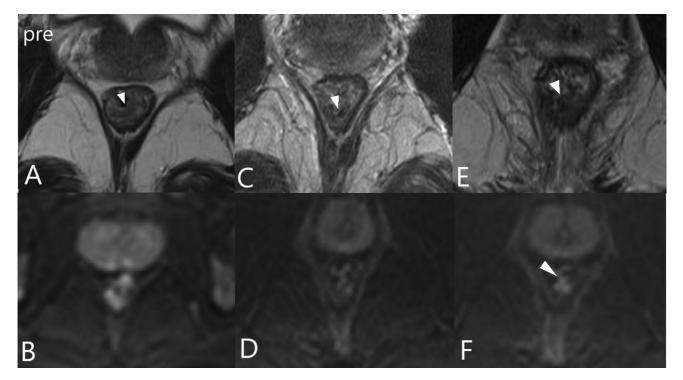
Regrowth after 9 months of complete response in an early stage (cT1, N0) low-rectal cancer following neoadjuvant long-course chemoradiotherapy (LCRT) with 54 Gy. (A, B) Baseline T2 high-resolution (HR) and diffusion-weighted imaging (DWI) (b800) show a left posterior semiannular intermediate signal intensity diffusion restricting early rectal cancer confined to the mucosa and submucosa (arrowhead). (C, D) Response assessment magnetic resonance imaging (MRI) T2 HR and b800 image of DWI at 6 months' follow-up showing a thin T2 scar (arrowhead) and no diffusion restriction. (E, F) MRI at 9 months of follow-up showed nodular tumor signal intensity thickening of the scar with diffusion restriction (arrowheads). The patient subsequently underwent abdominoperineal excision.
